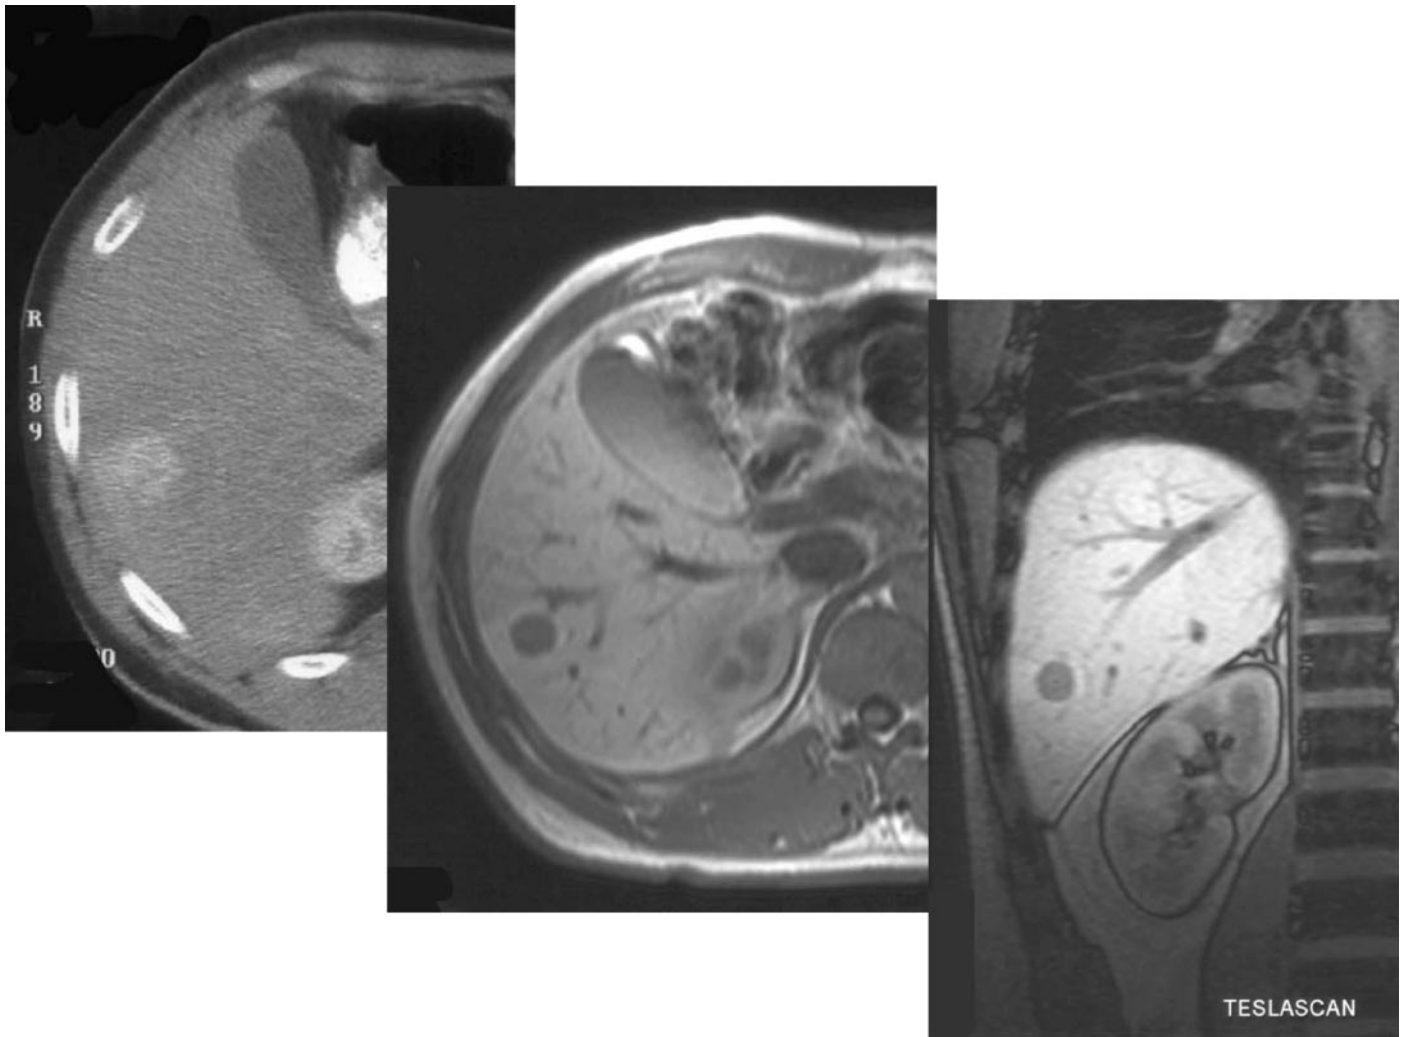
A comparison of CT (axial; *left*), conventional (axial; *middle*), and post-mangafodipir (Teslascan) (coronal; *right*) MRI scans in a patient with hepatic metastases from a midgut NET. The hepatic metastasis shows enhancement after contrast enhancement in the CT scan and is slightly more evident as a hypointense lesion on the T₁-weighted MRI. However, after iv mangafodipir, note how the surrounding parenchymal tissue selectively concentrates the contrast medium, demarcating the metastasis with greater clarity (courtesy of Dr. A. G. Rockall and Dr. R. Reznek, Department of Radiology, St. Bartholomew's Hospital, London, UK).
